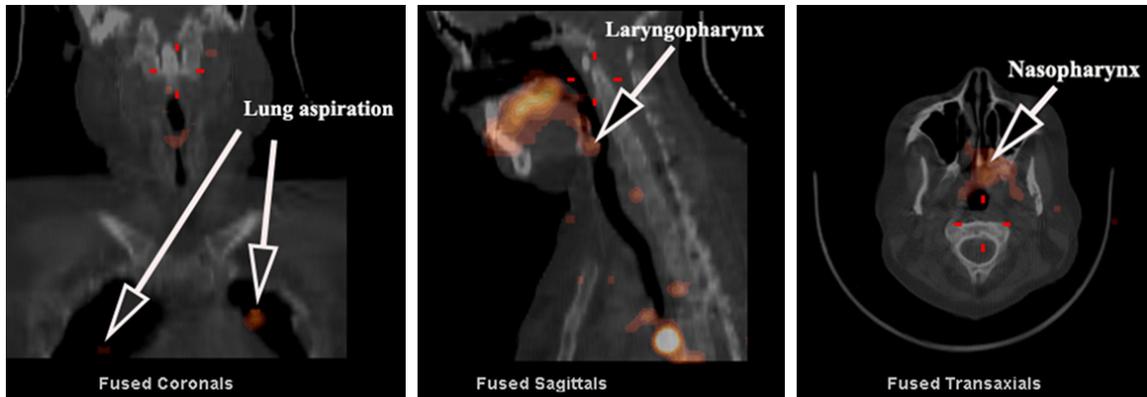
Abnormal patient study. The fused SPECT/CT images of the head, neck and chest demonstrate evidence of refluxate contaminating the oropharynx, laryngopharynx, and nasopharynx. There is also evidence of aspiration of refluxate into the lungs. These studies are routinely acquired in the patient studies. This could not be done with the asymptomatic volunteers due to restrictions of radiation exposure. It provides good orientation of the anatomy when the functional images are fused with the low-dose CT, allowing visualisation of hiatus hernias and possible compression of the cardiac structures.
